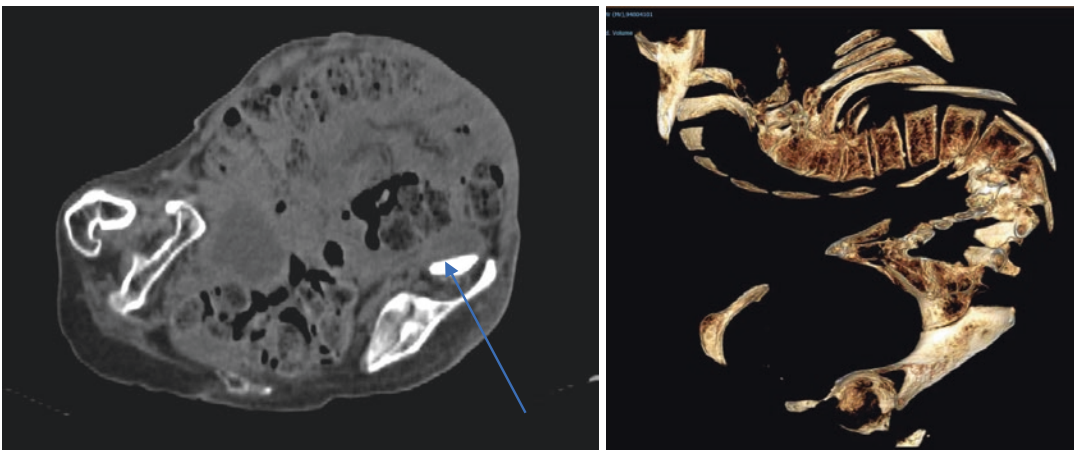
CT scan of patient with spina bifida with severe kyphoscoliosis. Blue arrow shows kidney with stone
